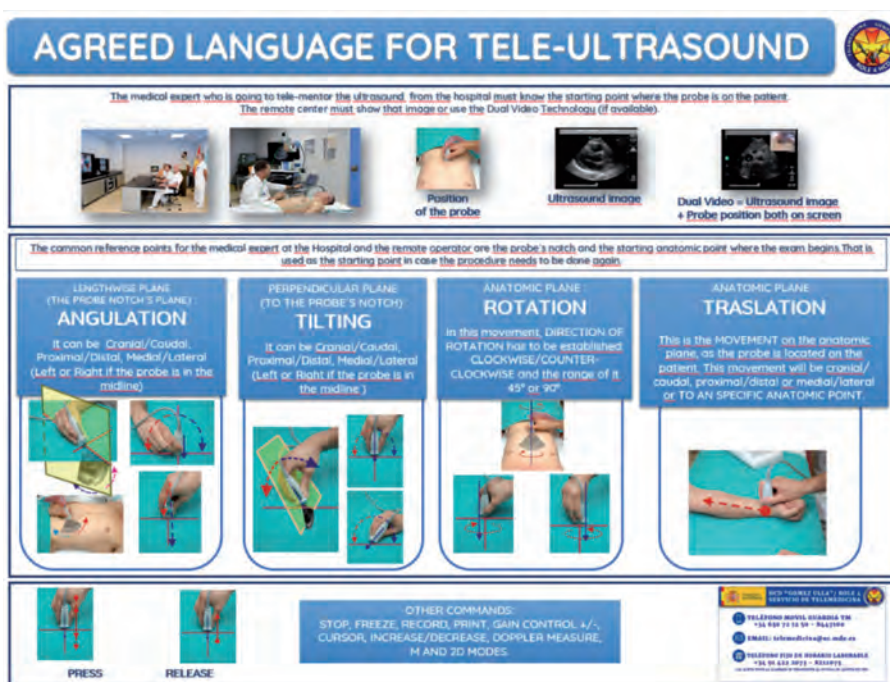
Agreed language for Tele-Ultrasound (Hernandez-Abadía, A., Molina, P. et al, not published).
